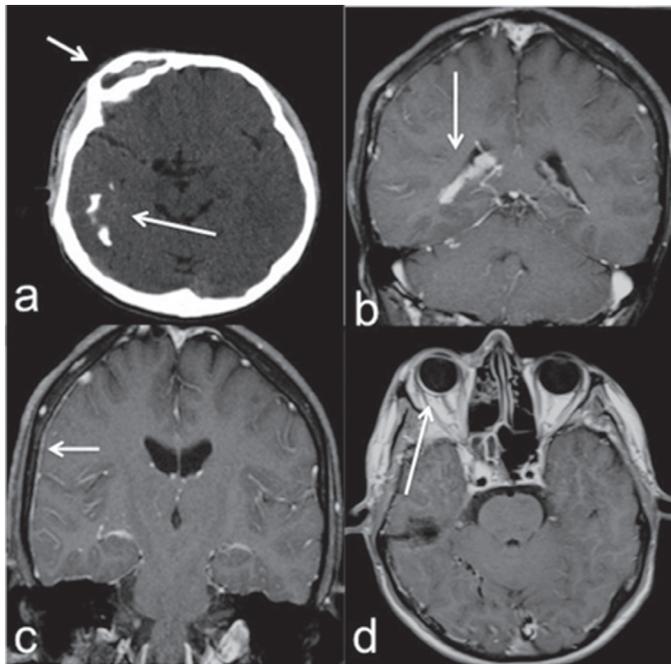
a) Axial cranial computed tomography image shows right temporal calcifications (long arrow) and hypertrophic right frontal sinus (short arrow). b) Contrast enhanced coronal T1 weighted image shows hypertrophy of right choroid plexus (white arrow). c) Contrast enhanced coronal T1 weighted image shows right mild dural thickening (white arrow). d) Contrast enhanced axial T1 weighted image shows right choroidal thickening in the right eye (white arrow)
